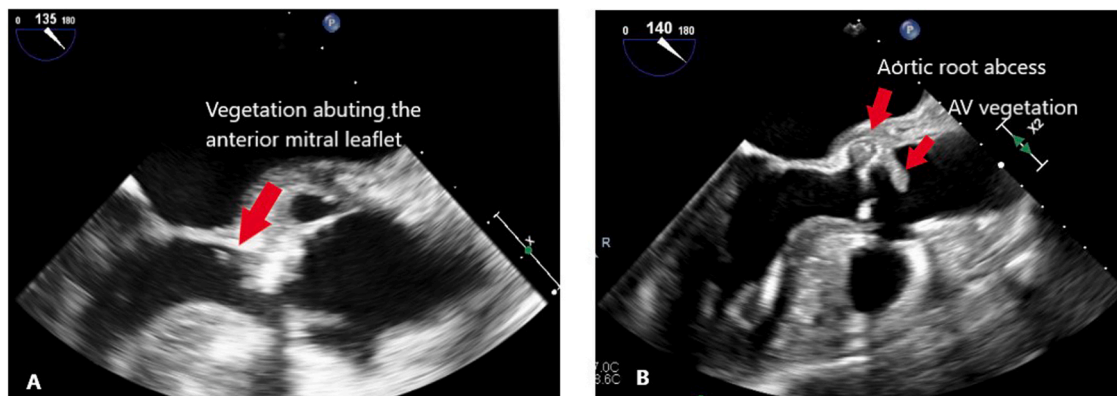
Transesophageal echocardiogram. A: Aortic valve vegetation extending into the LVOT and abutting the anterior mitral leaflet. B: Aortic valve vegetation with aortic root abscess.
